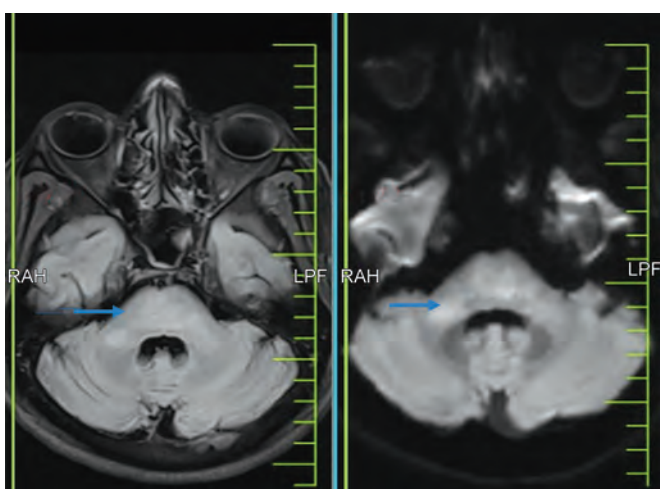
Showing hyperintensities in the cerebellar peduncle (extrapontine) on FLAIR and DWI images
